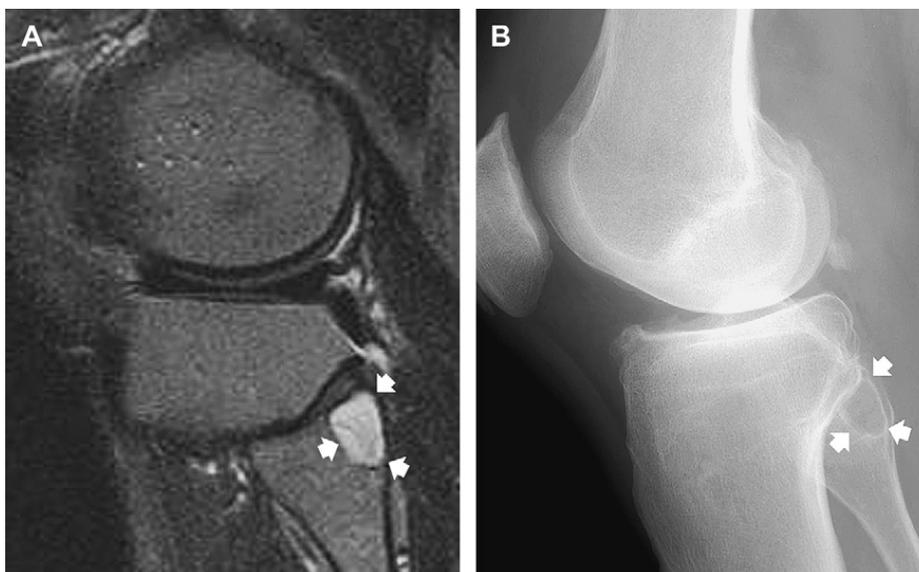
Subchondral cyst in the proximal fibula. (A) Sagittal T2-weighted (TR/TE; 2300/80) spin-echo MR image of the proximal fibula shows a focal high-signal intensity eccentric mass (*arrows*), immediately adjacent to the articular surface. The absence of significant associated degenerative arthritis suggested the possible diagnosis of a giant cell tumor. (B) Corresponding lateral radiograph shows the lesion to have a well-defined sclerotic margin (*arrows*), in keeping with a degenerative subchondral cyst.
